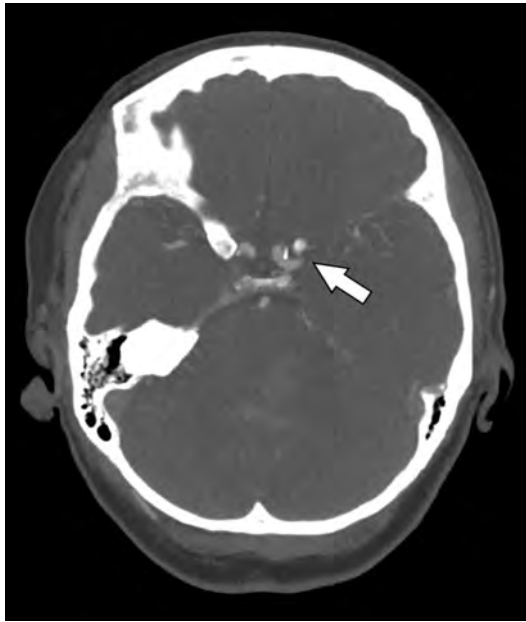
Computed tomography angiogram demonstrating left middle cerebral artery occlusion (arrow).
